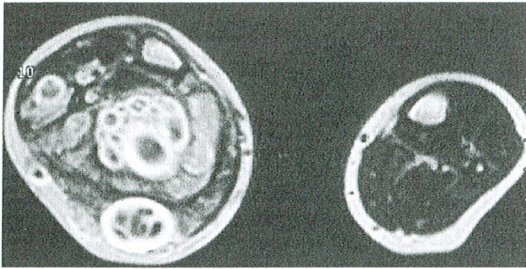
Axial pre- (A) and postgadolinium (B) T1-weighted MR images. The central portion of the lesion shows marked contrast enhancement (B).
